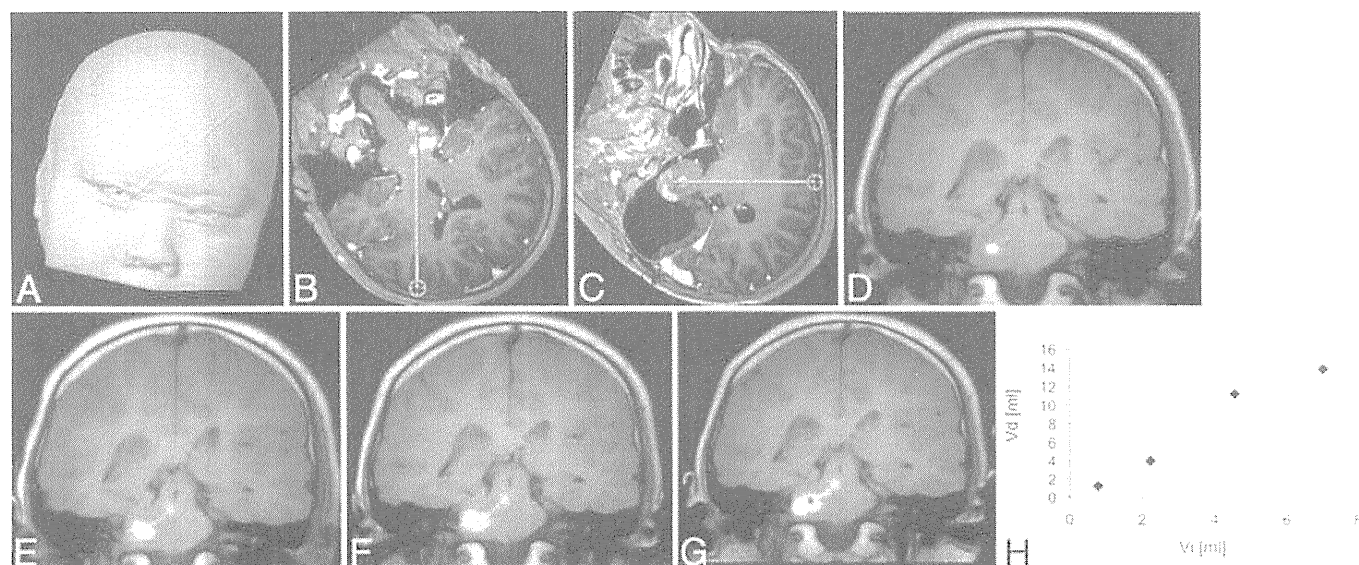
A–C: Route of the catheter tract developed. D–G: Coronal T1-weighted MR images obtained during the CED of ACNU. The images were acquired when the infusion volumes were 780, 2220, 4560, and 7020 μl , respectively. H: Volume of distribution (Vd) was plotted against volume of infusion (Vi) at 4 different time points.
